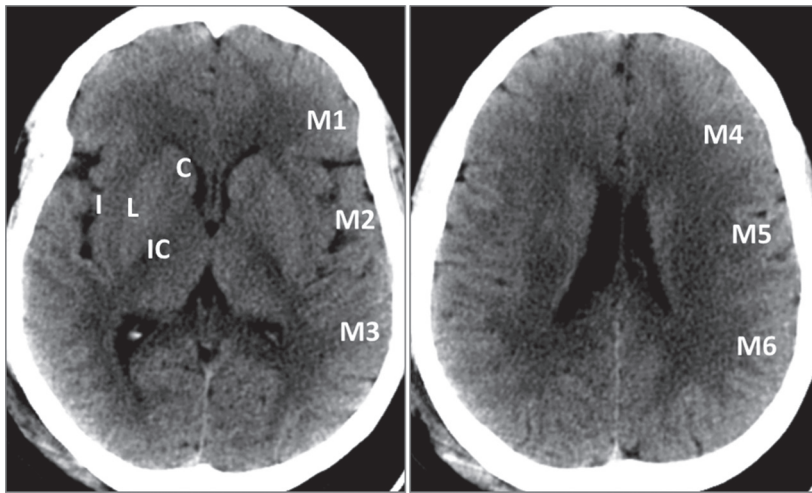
ASPECTS system. From a maximum of 10, 1 point is deducted for each of area of involvement. The cortical areas are designated M1–3 and M4–6 at the ganglionic and supraganglionic levels, respectively. The insula (I), the deep gray nuclei (C, caudate, L, lentiform nucleus), and the posterior limb of the internal capsule (IC) are the other structures. Also note optimal stroke window settings.
